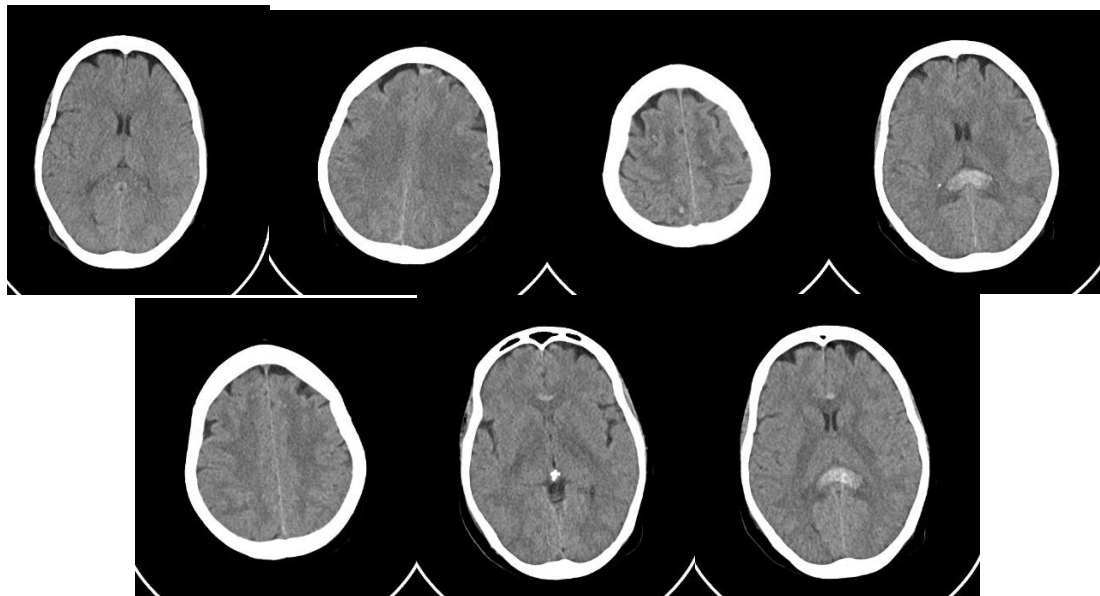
Non - Contrast CT Brain demonstrates multiple areas of bilateral cerebral acute intracranial hemorrhages including corpus callosum
